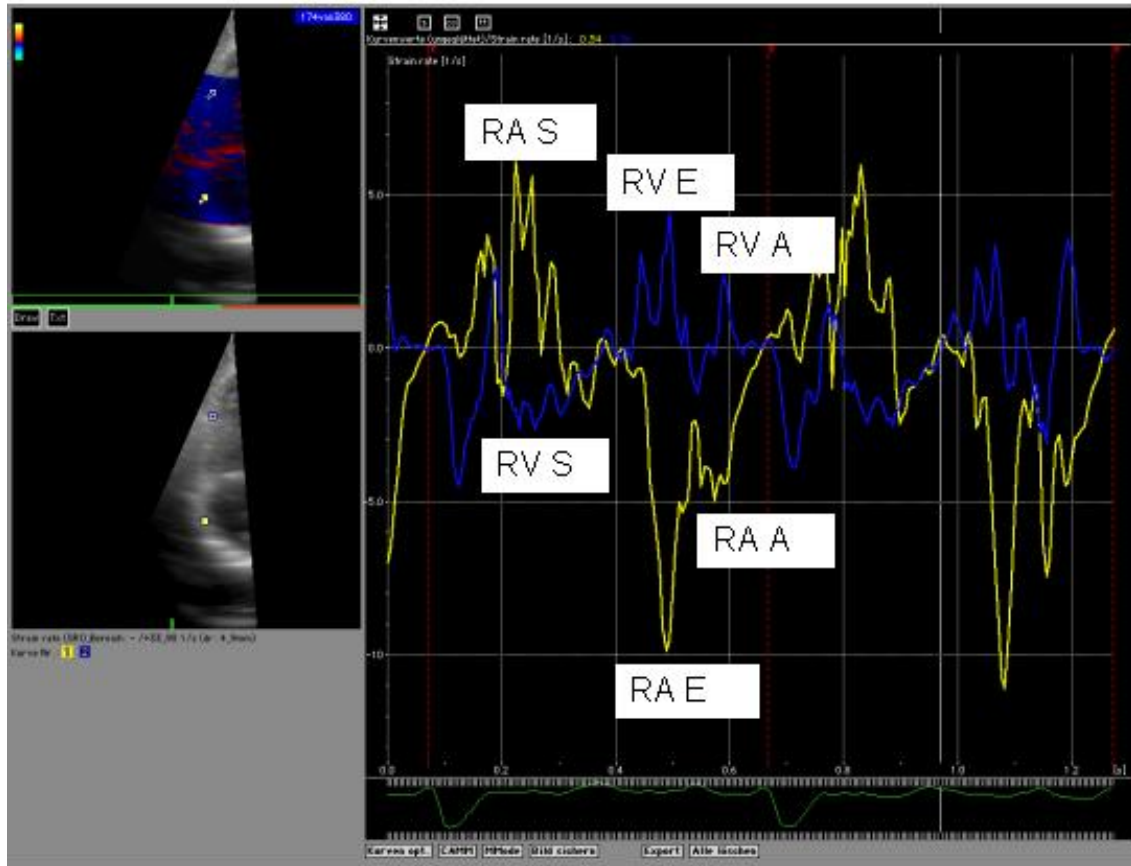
Tissue Doppler imaging derived strain rate curve obtained at the middle of the lateral walls of the atrium and ventricle respectively. In ventricular strain rate (blue curve) three distinct waves can be recognized: one negative systolic wave and two positive diastolic waves corresponding to early filling phase and late atrial contraction. The atrium strain rate curve is also characterized by the three main waves systolic, early diastolic and late diastolic waves, which coincided with the ventricular systolic, early diastolic and late diastolic periods respectively. The direction of atrial strain rate curve is the opposite to that of ventricular strain rate curve.
